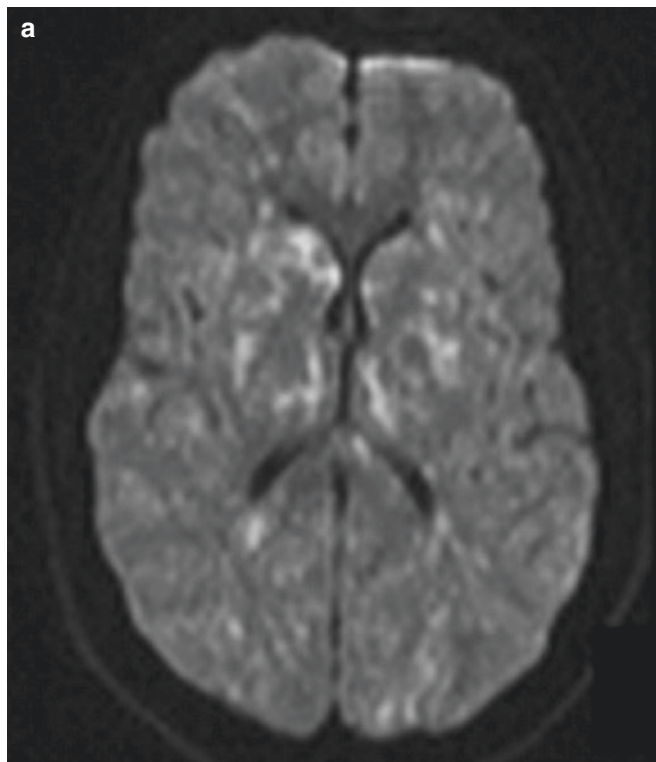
Cerebral fat embolism. Trauma patient with femur fracture and mental status decline. (a), Axial DWI shows numerous foci of diffusion restriction in the bilateral basal ganglia and cortices with a “star
